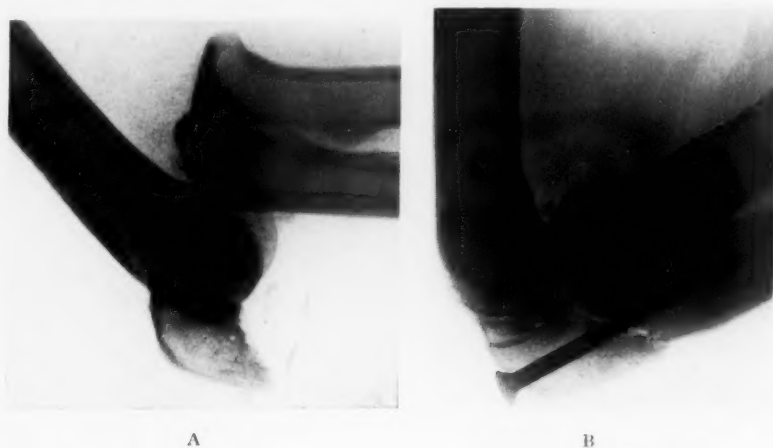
Patient R. J.: (A) A fracture of the olecranon with anterior displacement of both forearm bones. (B) Postoperative roentgenogram showing fixation of the fragments with a longitudinal screw.
